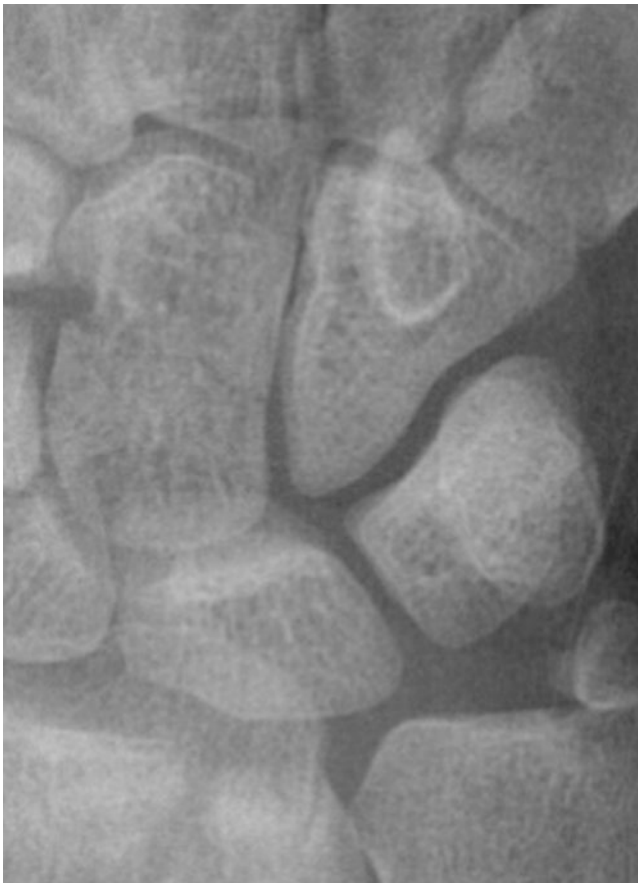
Radiographic view of a subtle non-displaced fracture to the capitate. The patient was a 20 year old football player at a major college, and complained of approximately 2–3 months of dorsal wrist pain. The patient presented for treatment after a hyperextension injury associated with sudden increased pain and swelling to the wrist
